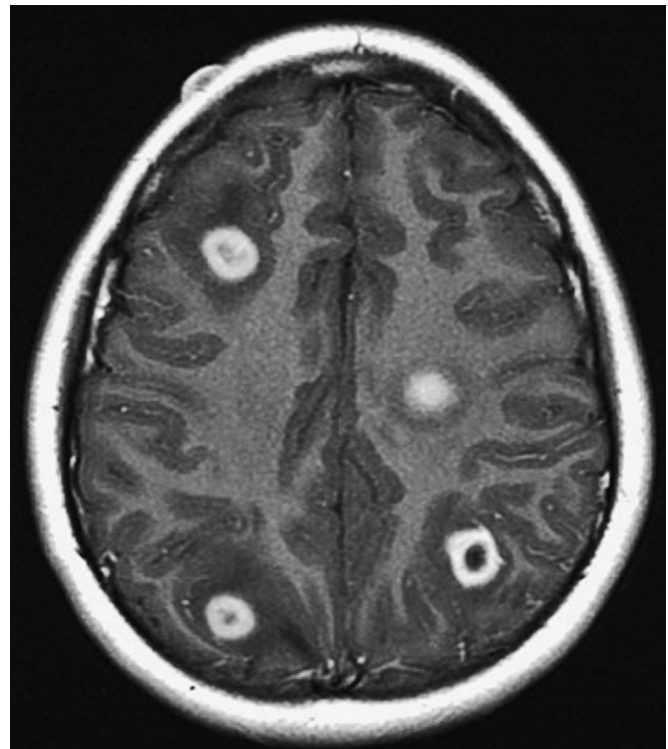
This magnetic resonance image demonstrates multiple brain abscesses in a pediatric patient with chronic granulomatous disease. A culture of the abscess material grew aspergillus.
